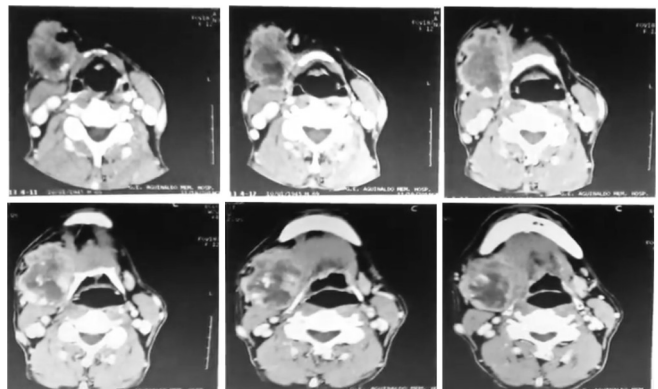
Representative CT Scan images of the patient from inferior to superior
